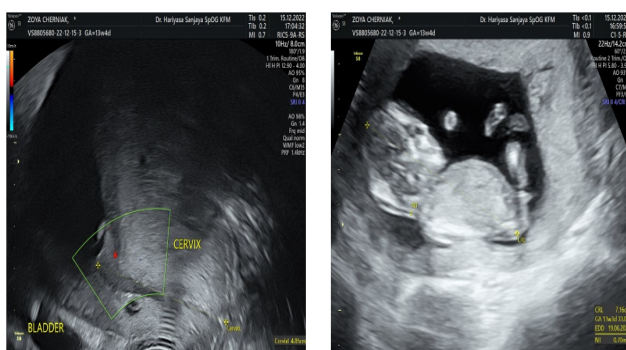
Ultrasound in 13 weeks 4 days.
